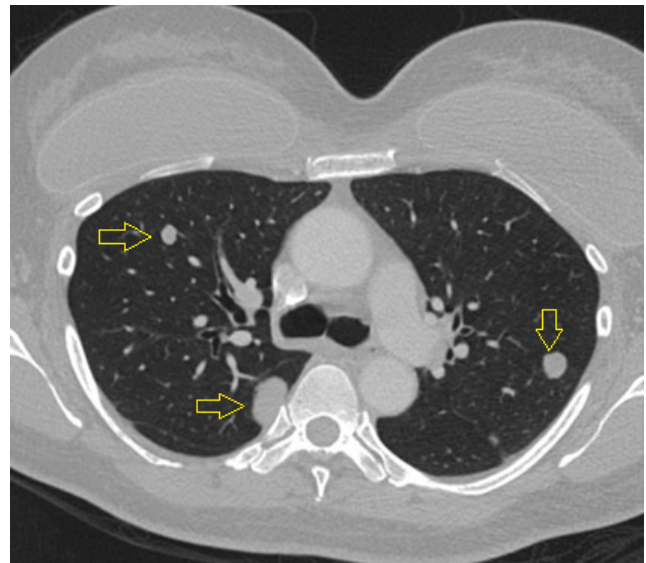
CT Slide 122/376 – Multiple pulmonary and paraspinal nodules
